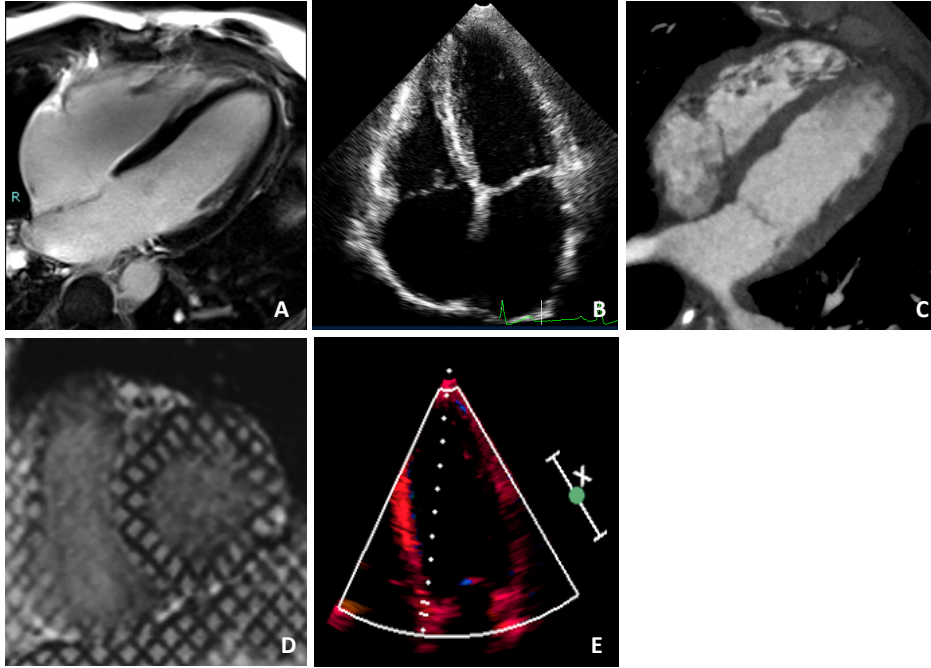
Comparison of Cardiac Imaging Modalities in the Four Chamber View. (A) cMRI, obtained from 3 Tesla Siemens Verio. SSFP cine sequence used. (B) CCT, obtained from a 320 sliced Toshiba CT scanner. (C) Echocardiography, obtained from a Philips ie33 with a S5-1 probe. Additional image demonstrating (D) cardiac tagged MRI in short axis and (E) Tissue Doppler Echocardiography of the LV have been included. Images Courtesy of Chris T. Sibley (A and D), Paul Leeson (B), Eduardo Lima (E)
